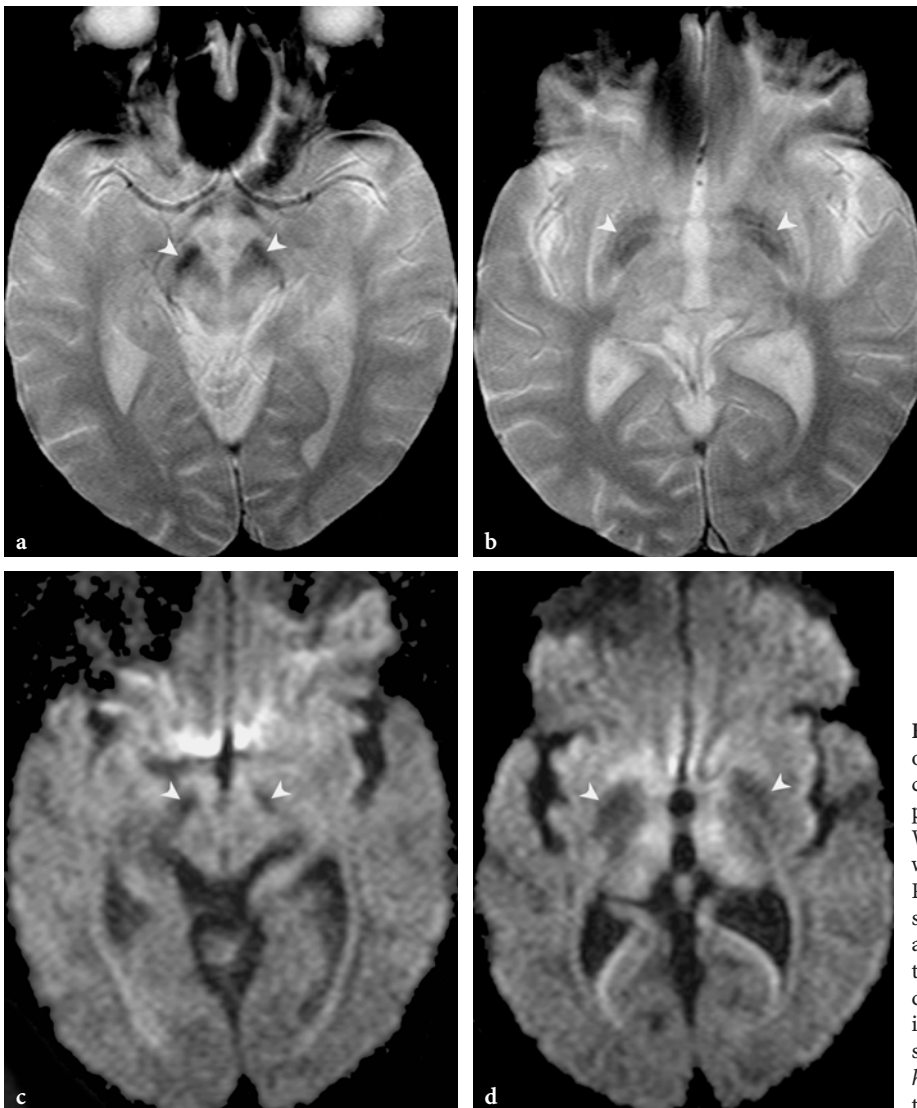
MR imaging demonstration of magnetically susceptible substances within globi pallidi and substantia nigra in Wilson disease. a,b Axial T2-weighted gradient-echo images. Prominent hypointensities are seen at the level of globi pallidi and pars reticulata of substantia nigra (*arrowheads*). c,d Axial diffusion-weighted echo-planar images ($B = 1000\text{s}$). Magnetic susceptibility artifacts (*arrowheads*) are further enhanced on these images
